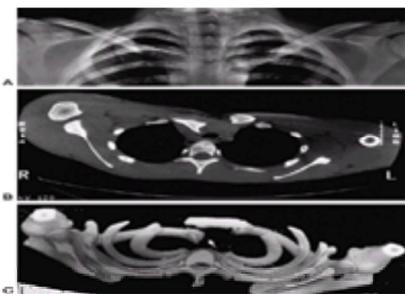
Sternoclavicular separation. This 14-year-old boy sustained an injury to the right clavicle during a wrestling match when his shoulder was compressed against his chest wall. He complained of shortness of breath, especially when he extended his neck. A: The anteroposterior radiograph demonstrates asymmetry of the sternal position of the clavicle. B: The computed tomographic scan demonstrates posterior displacement of the medial end of the right clavicle, which is in close proximity to the trachea. C: A three-dimensional reconstruction, with a cephalic projection, demonstrates the posterior and midline displacement of the clavicle.
